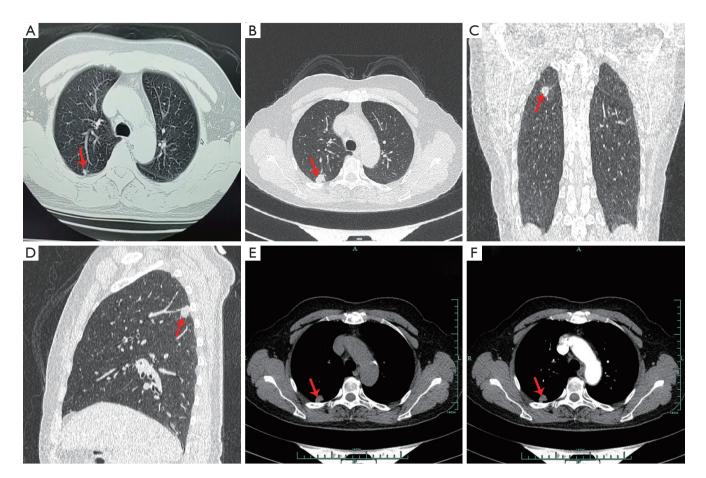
Preoperative chest CT scan images. (A) The CT scan shows a round 6 millimeter solid nodule located in the peripheral region of the right upper lobe (posterior segment); (B) the CT scan shows that the nodule has increased to 14 millimeter after 20 months; (C) coronal view of the nodule; (D) sagittal view of the nodule; (E) mediastinal window reveals the pulmonary nodule; (F) the enhanced CT scan shows mild to moderate enhancement of the nodule, and no enlargement of hilar or mediastinal lymph nodes. The red arrows in the image indicate the primary tumor. CT, computed tomography.
